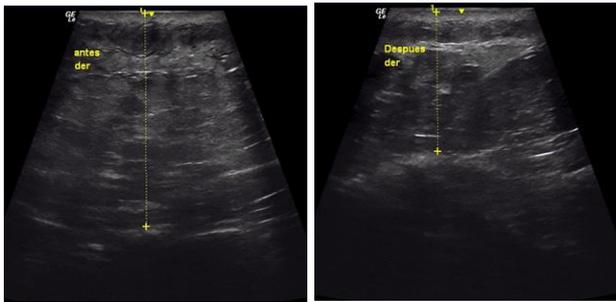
Ultrasound evaluation of tissue before (left) and after (right) single session with combined Er:YAG and Nd:YAG laser treatment shows significant reduction
